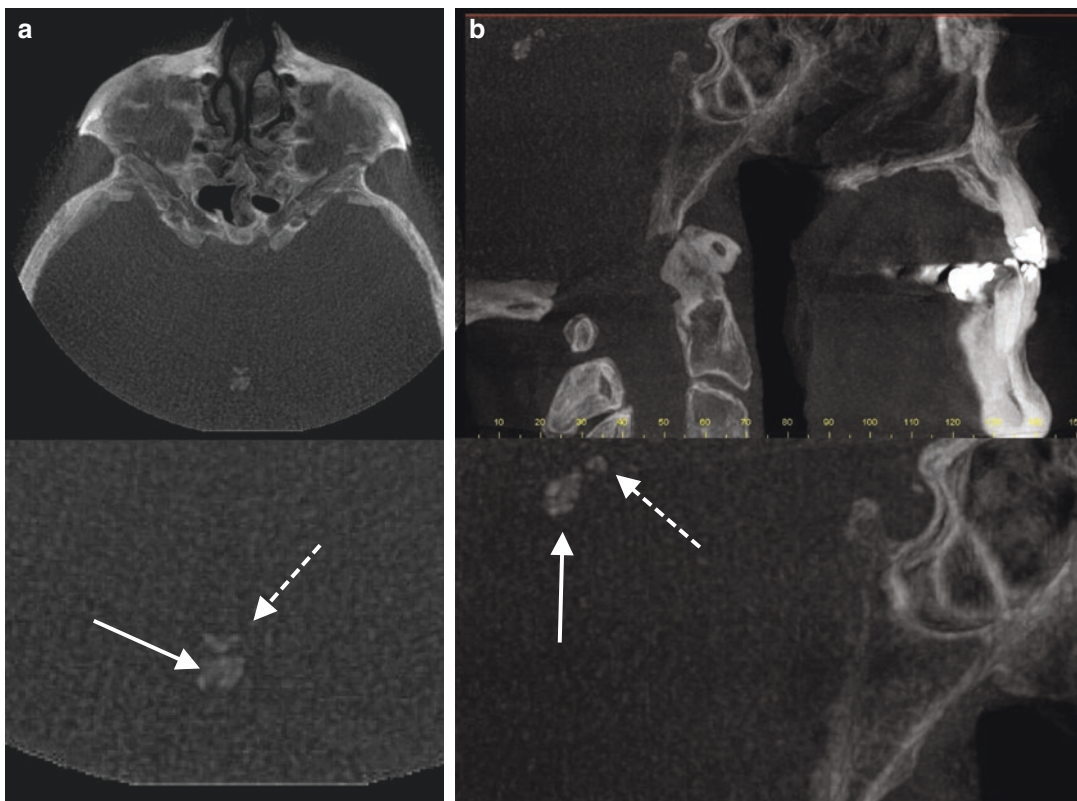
Coronal (*left column*) sagittal (*middle column*), and axial (*right column*) 10 mm thick MIP CBCT images of two patients (a, b) demonstrating the typical appearance and location of calcified pineal gland/habenula
